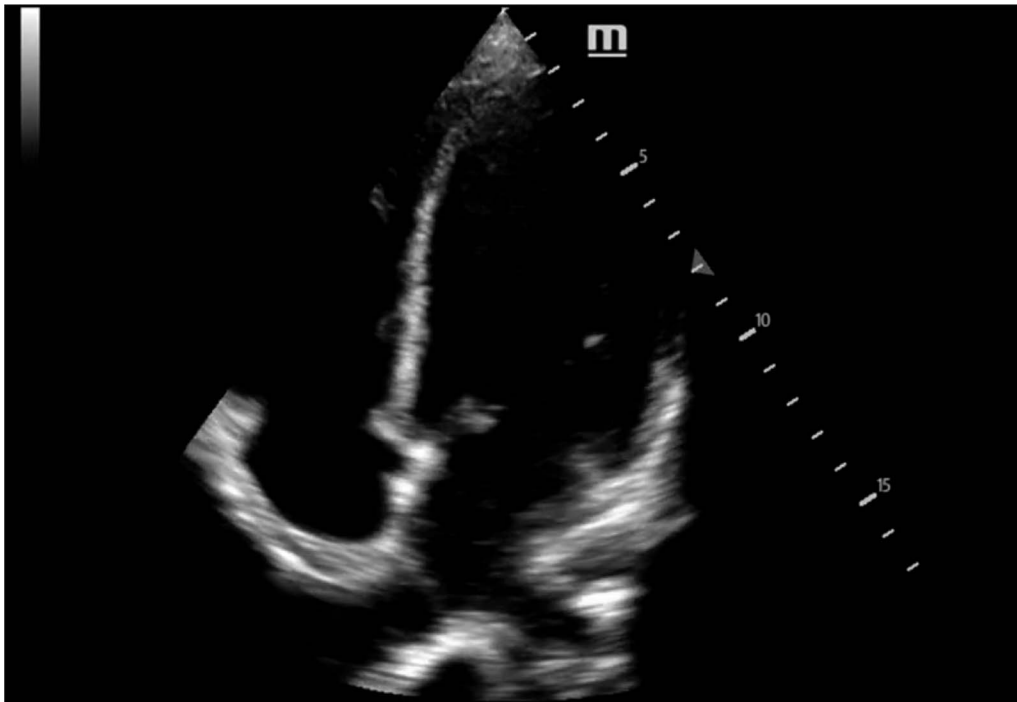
Apical 4 chamber view shows a dilated left ventricle. The clip of this still image shows the mitral valve leaflet not slapping the septum wall as it should if normal function (supplemental video media attached, Video 1, <http://links.lww.com/PEC/A785>).
